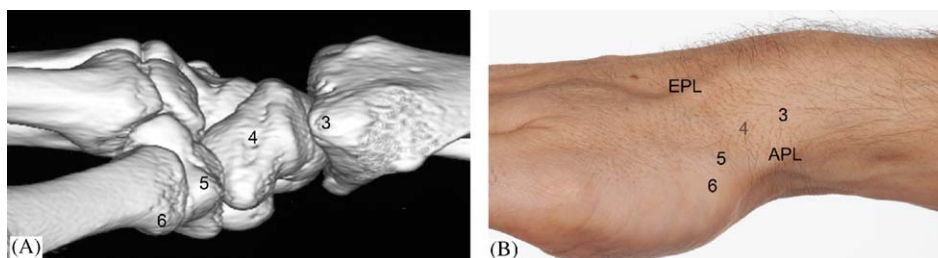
Lateral (radial) view of the carpus and wrist as 3D CT reconstruction (A) and clinical photograph (B). Landmarks in both figures are—(3) radial styloid, (4) waist of scaphoid, (5) trapezium, (6) base of the first metacarpal, EPL: extensor pollicis longus, APL: abductor pollicis longus and extensor pollicis brevis.
